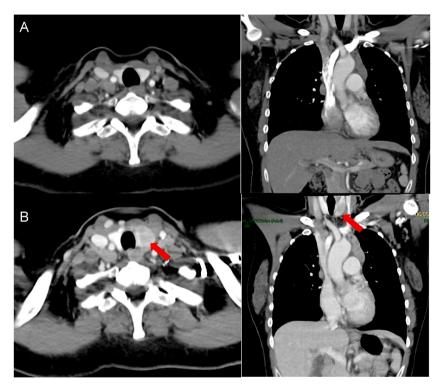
(A) 3/2/20 CT Thorax: Normal thyroid, axial and coronal images. (B) 6/5/20 CT Thorax: New left thyroid lobe hypodense nodule (arrow), axial and coronal images.
